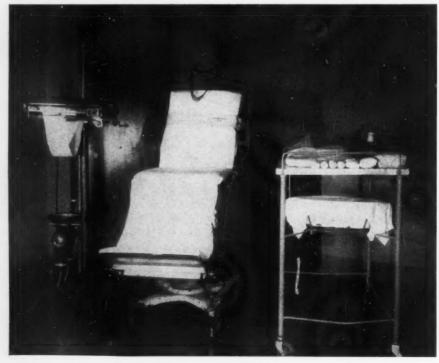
shows an adjustable operating table with x-ray tube and stand.
